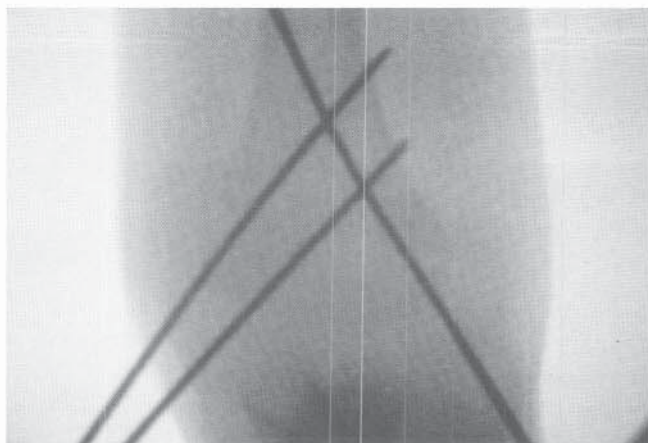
AP radiograph showing fracture pinned using the two lateral pin, selective medial pin technique.
